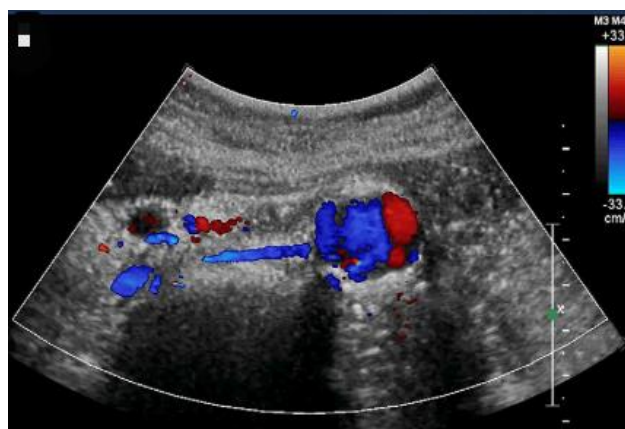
An aortic aneurysm is characterised by swirling flow on Colour Doppler ultrasound. (Reproduced from Prager *et al.*¹⁵⁷ with permission from Springer Nature)
